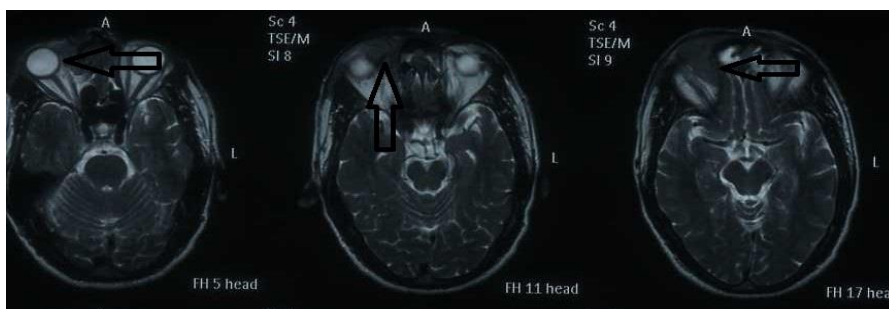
Axial T2 weighted MRI image showing hypointense lesion at right side of forehead reaching upto medial canthus of right eye (arrows)
